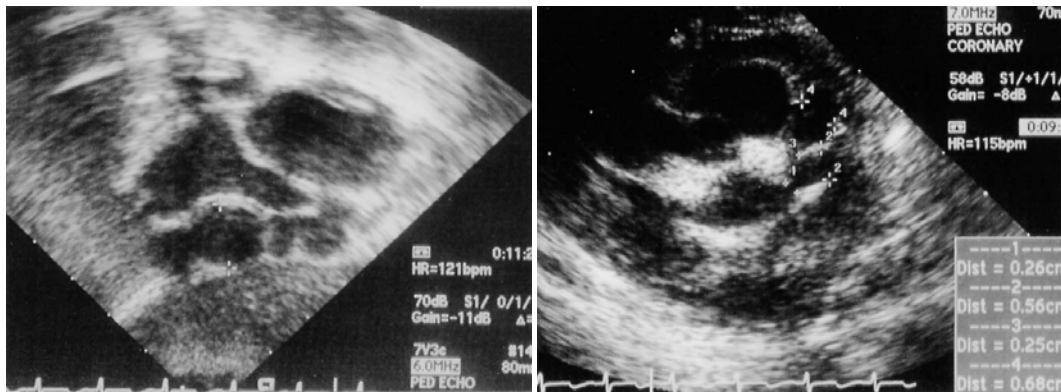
The echocardiographic findings at the 18th day of admission show a giant aneurysm at the right coronary artery that was as large as the aortic annulus, and fusiform aneurysm in left coronary arteries are also shown.
